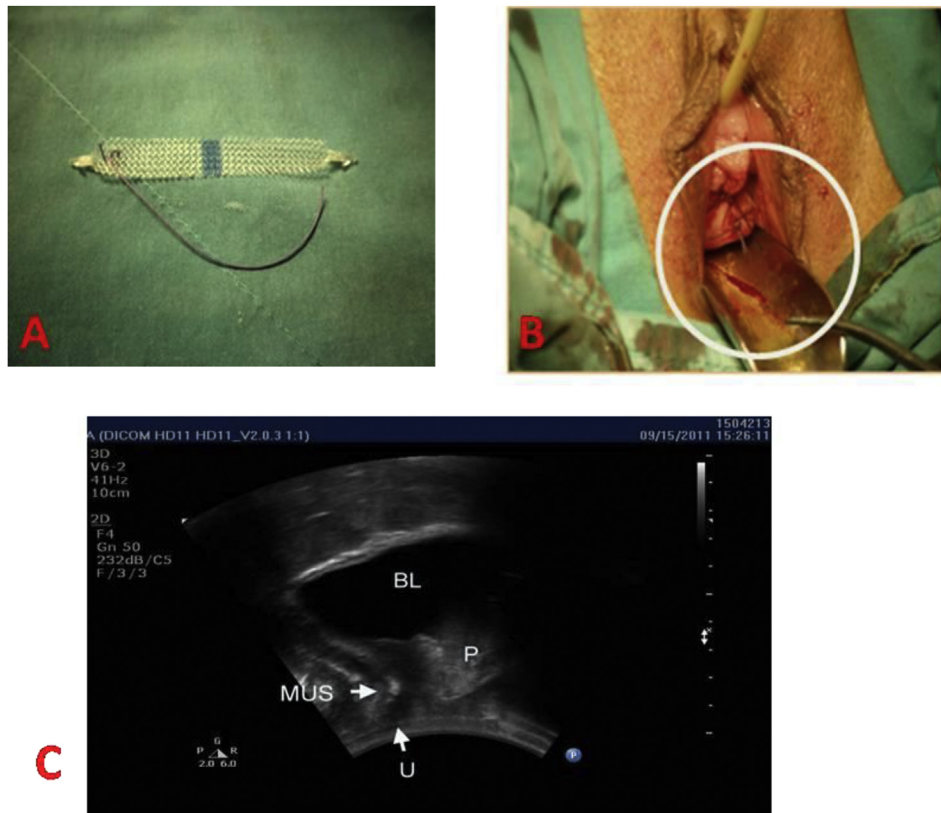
(A) TRS is prepared by appending a 1-0 absorbable polyglactin (Vicryl) suture to one side of the MiniArc sling fiber attached to the anchoring tip. (B) The free end of the TRS suture exteriorized through the anterior vaginal surface epithelium incision, which was closed with a 2.0 polyglactin suture. (C) Introital ultrasound demonstrated urethral indentation or urethral elevation over the suburethral sling in a transverse view. BL = bladder; BN = bladder neck; MUS = midurethral sling (MiniArc sling); P = pubic; TRS = tension-releasing suture; U = urethra.
